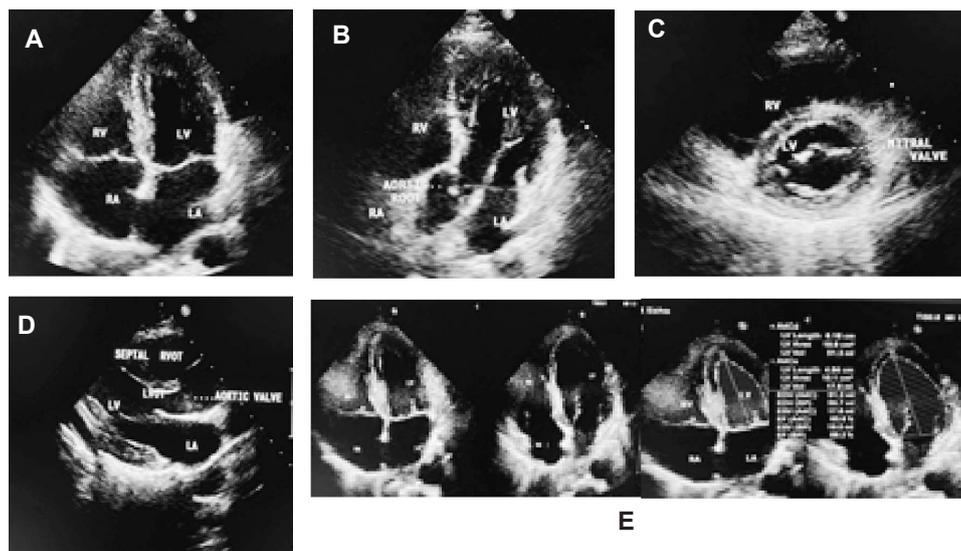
Echocardiography technique. A, 2D echocardiography; apical 4-chamber view. B, 2D echocardiography; apical 5-chamber view. C, 2D echocardiography; parasternal short-axis view. D, 2D echocardiography; parasternal long-axis view., E, 4-chamber to measurement Simpsons methode during systole and diastole (RV, right ventricle; LV, left ventricle; RA, right atrium; LA, left atrium; RVOT, right ventricular outflow tract; LVOT, left ventricular outflow tract; AV, aortic valve; IVSd, interventricular septum thickness at end-diastole; LVIDd, left ventricular internal diameter in diastole; LVPWd, left ventricular posterior wall thickness at end-diastolic; IVSs, interventricular septum thickness at end-systole; LVIDs, left ventricular internal diameter at end-systole; LVPWs, left ventricular posterior wall thickness at end-systole)
